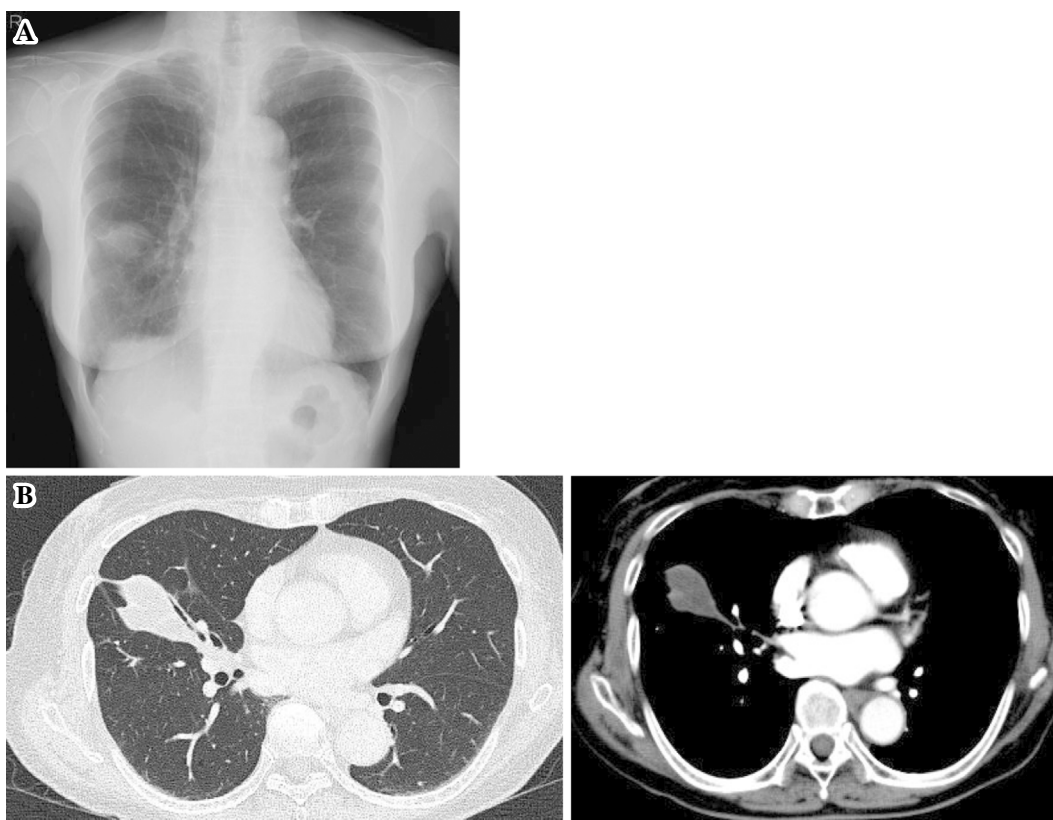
Chest X-ray (A) and contrast-enhanced computed tomography (B) on admission.
